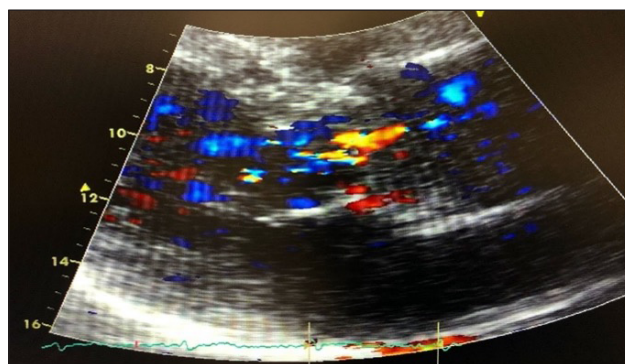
Pre-COVID-19 transthoracic echocardiogram showing mild aortic regurgitation.
